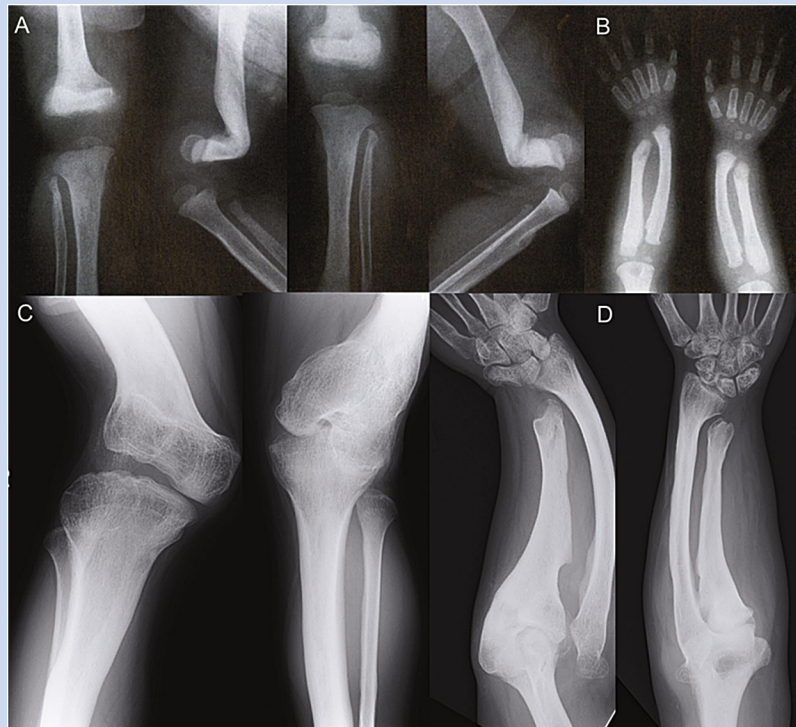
A: Radiographs of the knees at age 22 months: the distal femora show sharp posterior angulation. The proximal fibulae are constricted. A pseudo-fracture is noted in the right proximal fibula. B: Radiographs of the forearms at age 3 3/12 years: The radii and ulnae are mildly bowed. The distal ulnae are constricted along with pseudo-fractures. C: Radiographs of the knees at age 19 years: Valgus deformity is remarkable. Irregular contours are seen in the left femur and right tibia. D: Radiographs of the forearms at age 27 years: The radii and ulnae are bowed, and the proximal radii are dislocated. The distal ulnae are narrow, while the proximal ulnae appear mildly thick. Mild ossification is seen in the radioulnar interosseous membranes. A and B are reproduced from AJMG 84:320–329 [1999] by permission of the publisher.
